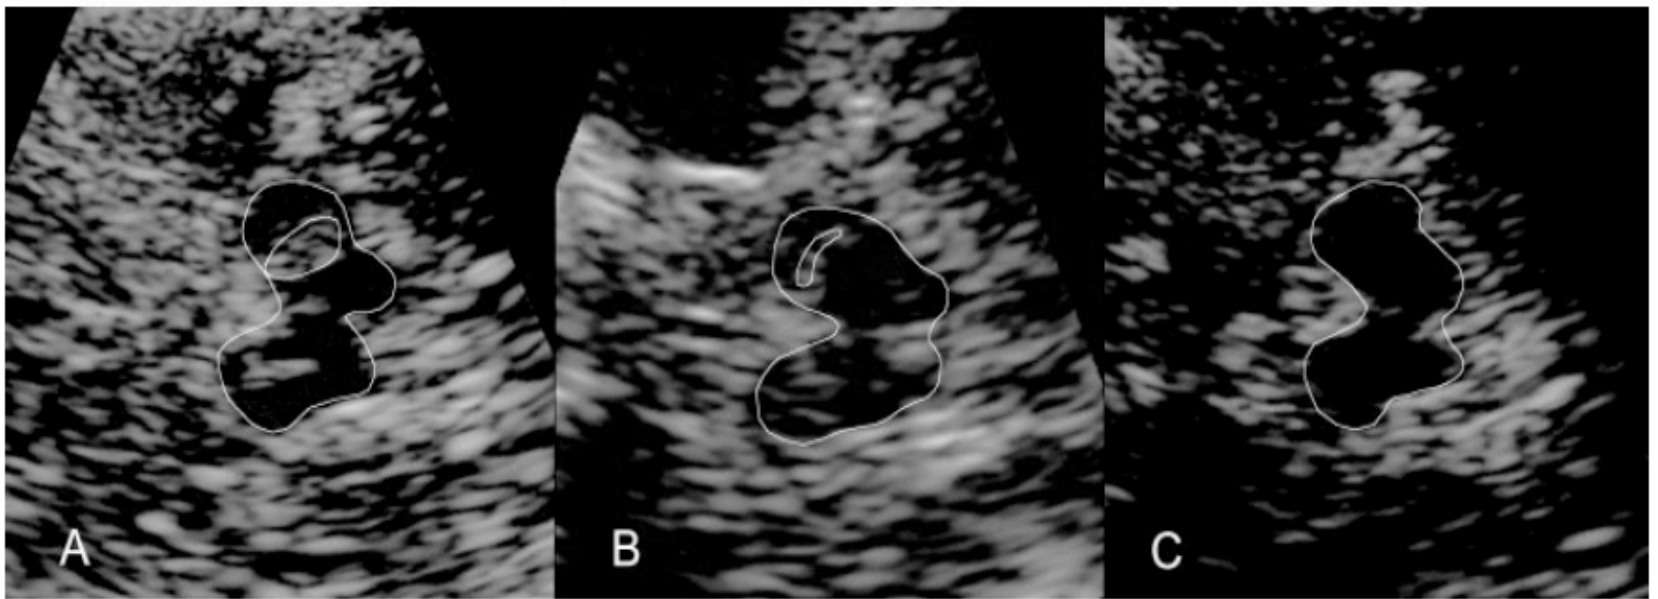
Typical examples of transcranial ultrasound appearances (axial scanning plane) in three patients. (A) Patient with Parkinson's disease (PD). (B) Normal control subject (CO). (C) Patient with restless legs syndrome (RLS). Midbrain and areas of hyperechogenicity encircled in (A) and (B) on the side of insonation.
